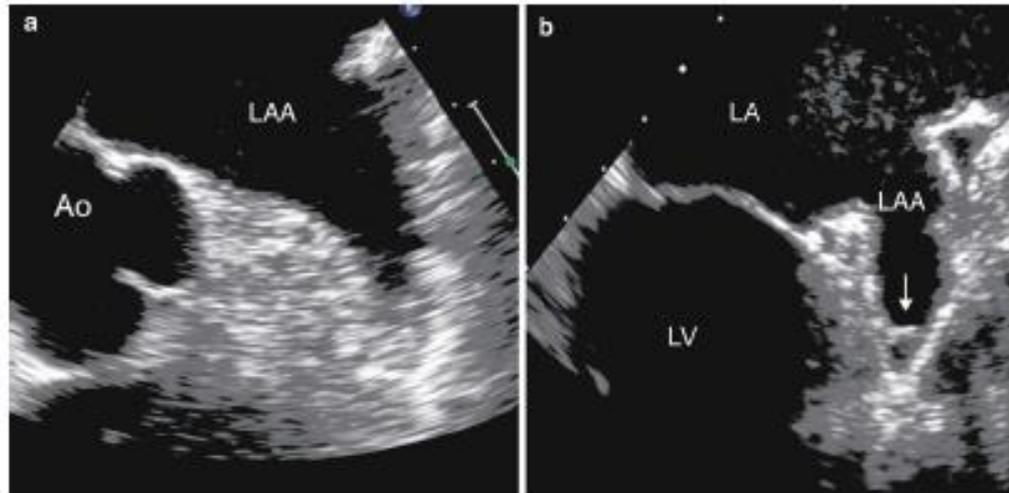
Two-dimensional transesophageal images (mid-esophagus) of two sectional planes at (a) 20–30° and (b) 80–90°. Both sections show an LAA with a triangular form. The *arrow* indicates a musculus pectinatus
